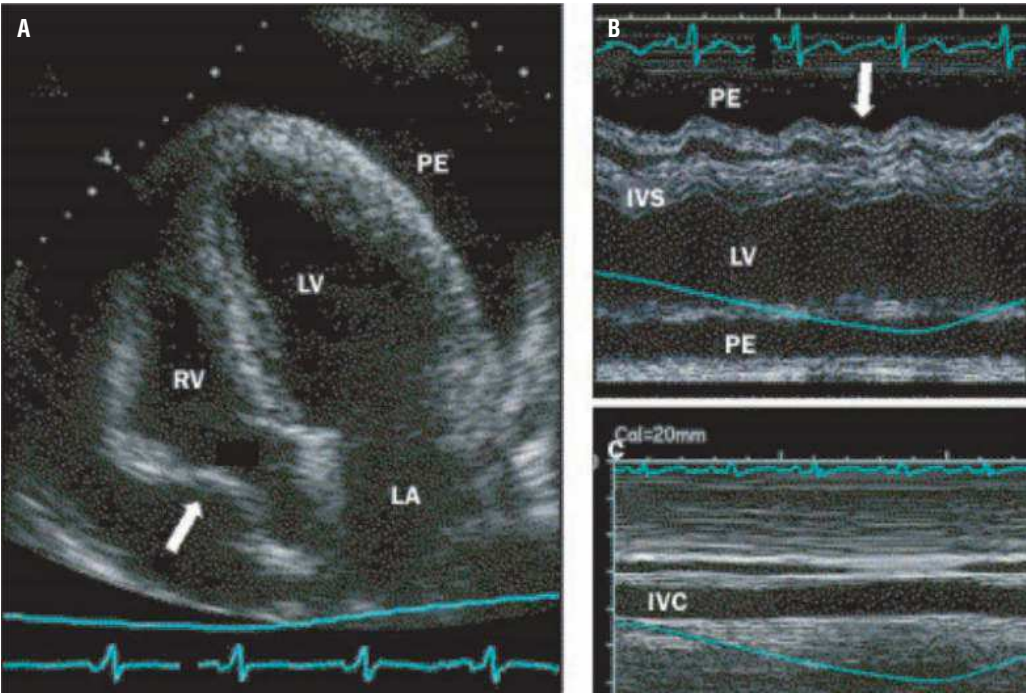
Echocardiographic evidence of cardiac tamponade. Echocardiographic images of large pericardial effusion with features of tamponade. (A) Apical four-chamber view of LV, LA, and RV that shows large PE with diastolic right-atrial collapse (arrow). (B) M-mode image with cursor placed through RV, IVS, and LV in parasternal long axis. The view shows circumferential PE with diastolic collapse of RV free wall (arrow) during expiration. (C) M-mode image from subcostal window in same patient that shows IVC plethora without inspiratory collapse. Reprinted with permission from Elsevier (*The Lancet*, 2004, vol. 363, pp. 717–27).
